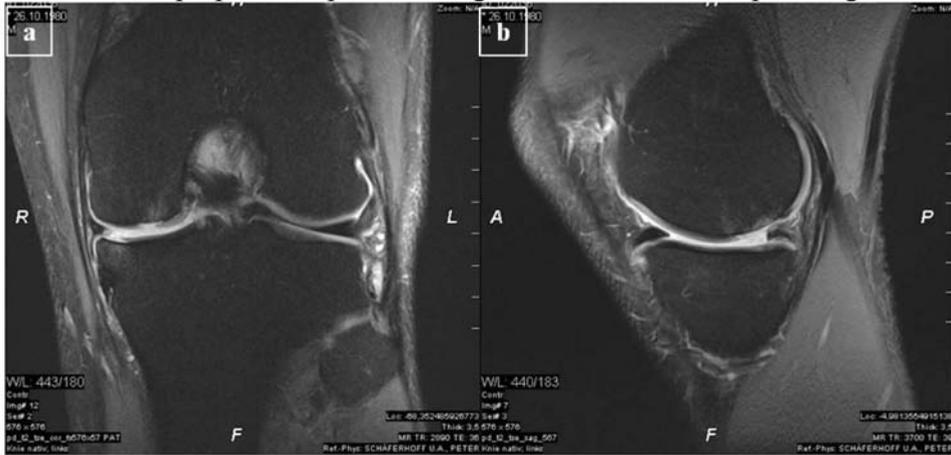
(a+b) MRI preoperative with cartilage defects of the medial tibial and femoral side.
